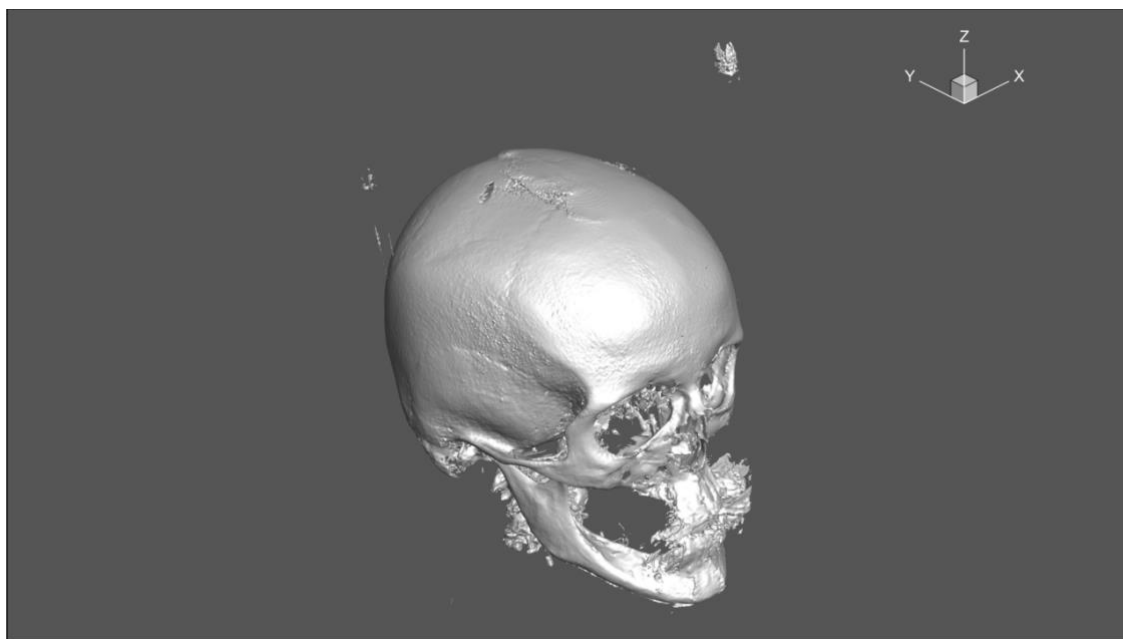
Volumetric stereo-animation of computed tomography of a patient created using the camera flyover method.
